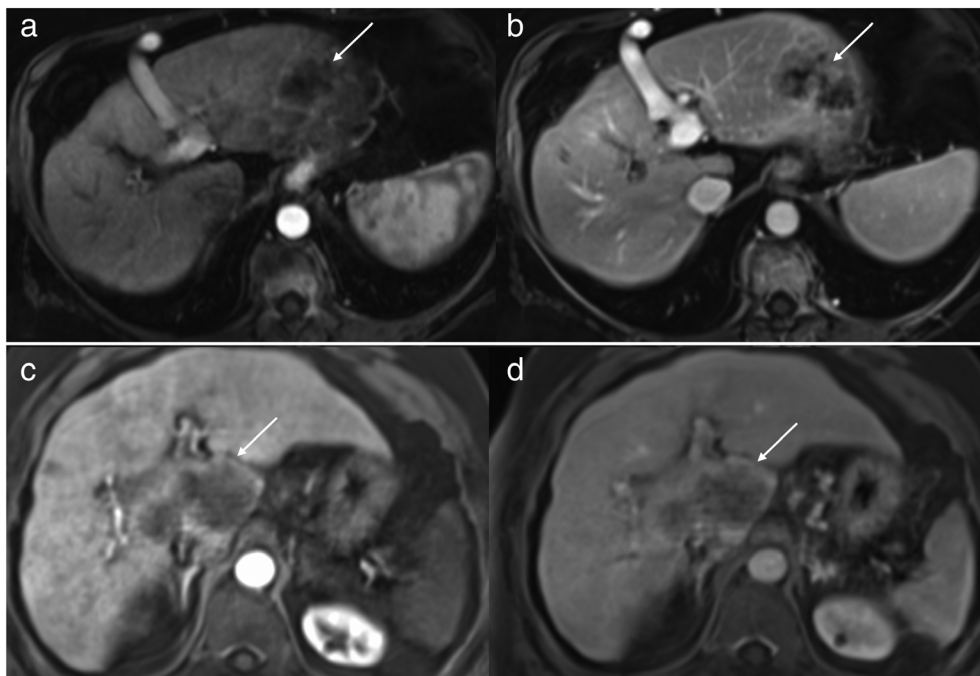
LR-M hepatocellular carcinoma and LR-M intrahepatic cholangiocarcinoma. Arterial (a) and portal venous (b) phase T1-weighted fat suppressed 3D GRE images after the administration of gadobenate dimeglumine in a 60-year-old female with hepatitis C cirrhosis demonstrates a 6.0 cm observation (arrows) in segment 2 with arterial-phase rim hyperenhancement persisting in the portal venous phase, categorized as LR-M. At biopsy, this lesion was hepatocellular carcinoma. Arterial (c) and portal venous (d) phase images after the administration of gadobenate dimeglumine in a 72-year-old male with nonalcoholic steatohepatitis (NASH) cirrhosis demonstrates an 8.5 cm observation (arrows) in segments 8, 4a, and 1 with arterial-phase rim hyperenhancement persisting in the portal venous phase, categorized as LR-M. At biopsy, this lesion was intrahepatic cholangiocarcinoma. The patient with LR-M HCC died 90 days after diagnosis and the patient with LR-M iCCA died 72 days after diagnosis due to tumor progression.
